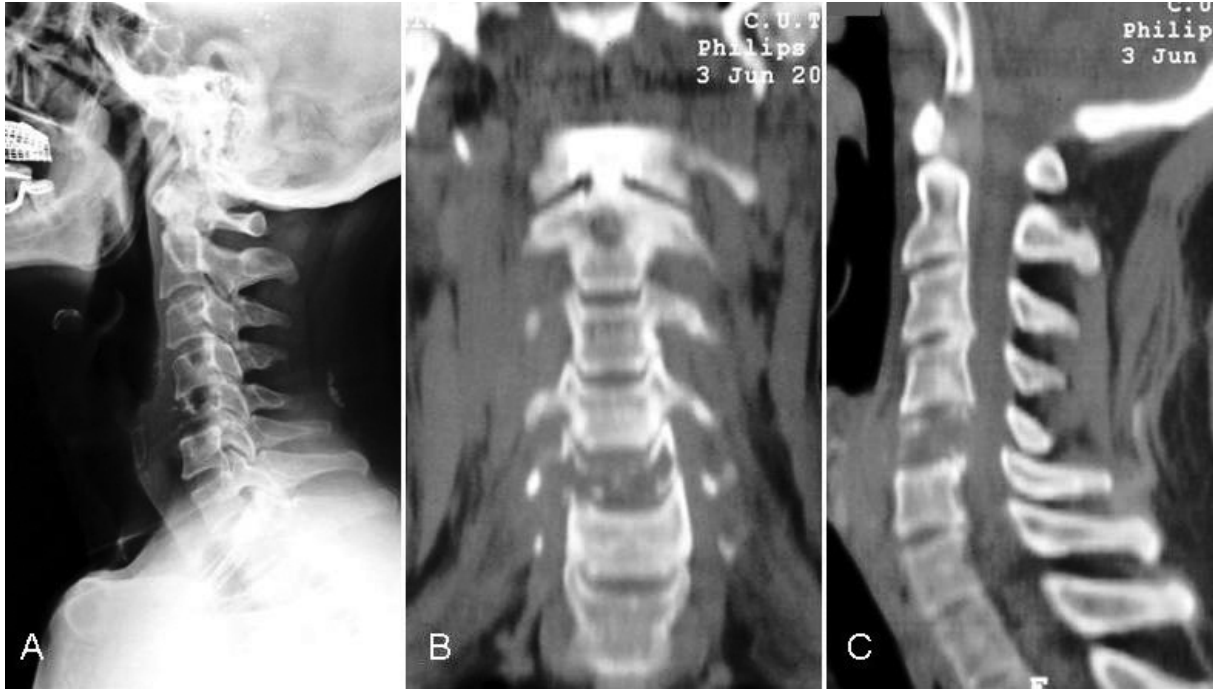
Preoperative lateral cervical X-ray (A), coronal CT (B) and sagittal CT (C) shows osteolytic lesion in vertebra corpus.
